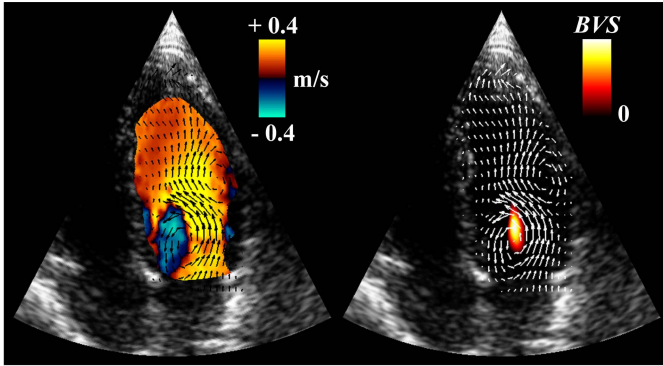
Left: Doppler field in the left ventricle (red/blue color map) with the corresponding velocity field given by the VFM (black arrows). Right: Corresponding map of the BVS for the same high-frame-rate sequence, as returned by Doppler vortography. The local extremum of the BVS returns the location of the vortex core. For comparison, the overlaid white arrows represent the VFM map of the left panel.
